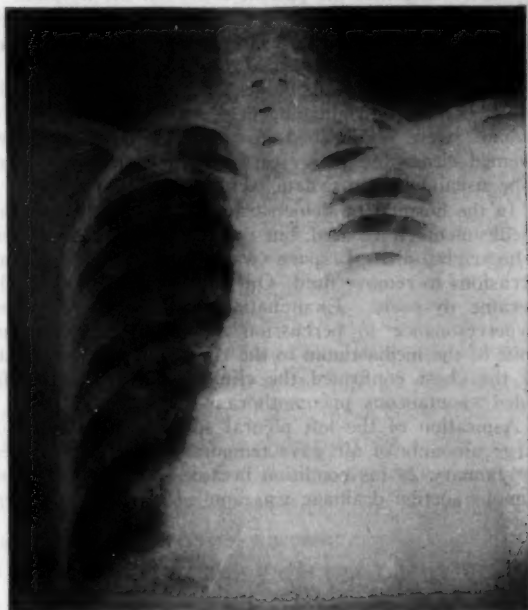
(case 2).—Roentgenogram taken Jan. 26, 1939, three days before death. The hydrothorax on the right has increased despite thoracenteses, and pneumothorax is present on the left side.
